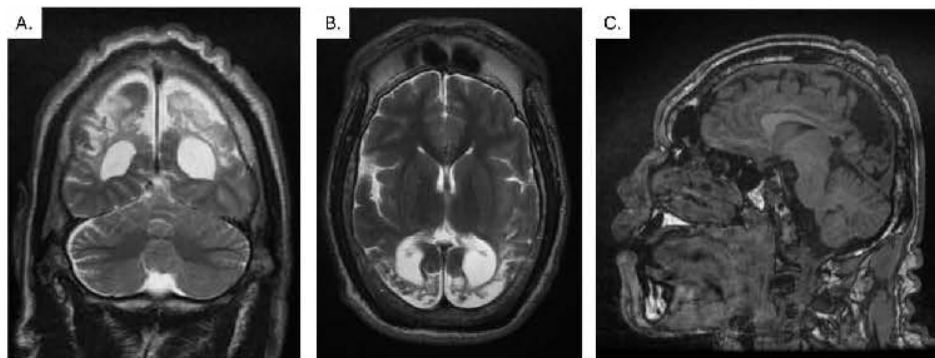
Brain magnetic resonance images
